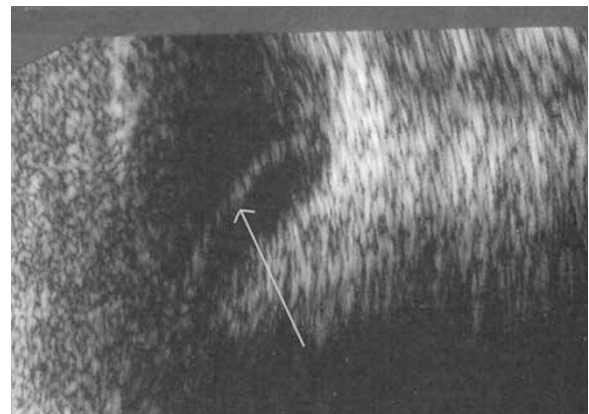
Low-frequency B scan ultrasonographic appearance of patient 1 showing an exudative retinal detachment (white arrow).
